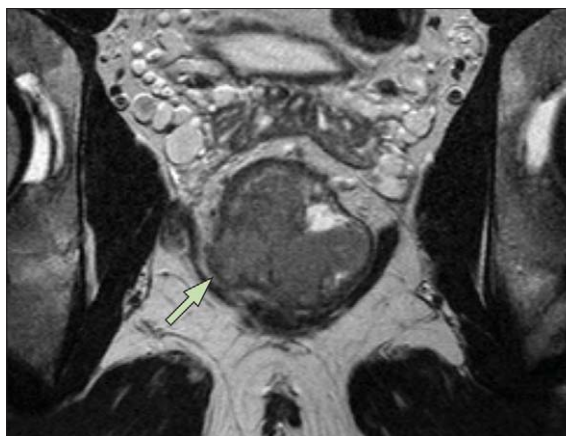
Axial T2-weighted MRI of T3 low rectal tumour with infiltrative border (arrow)
